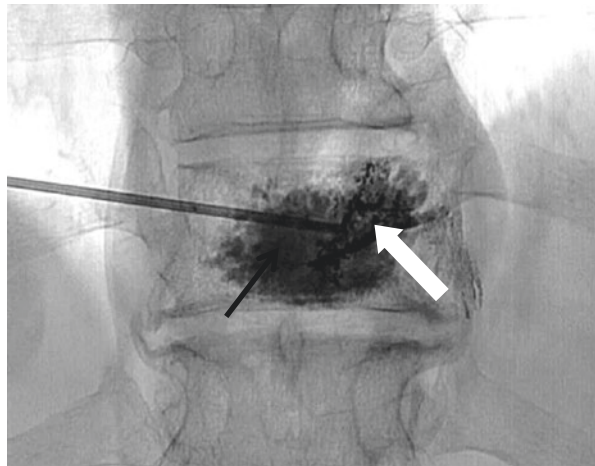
Same patient as before, AP radiograph; VPL has been completed (black arrow) and the trocar is removed while injecting the Onyx (recognizable because of its higher radiopacity than PMMA) that fills the vascular channels of epidural sector of the hemangioma (white arrow)
